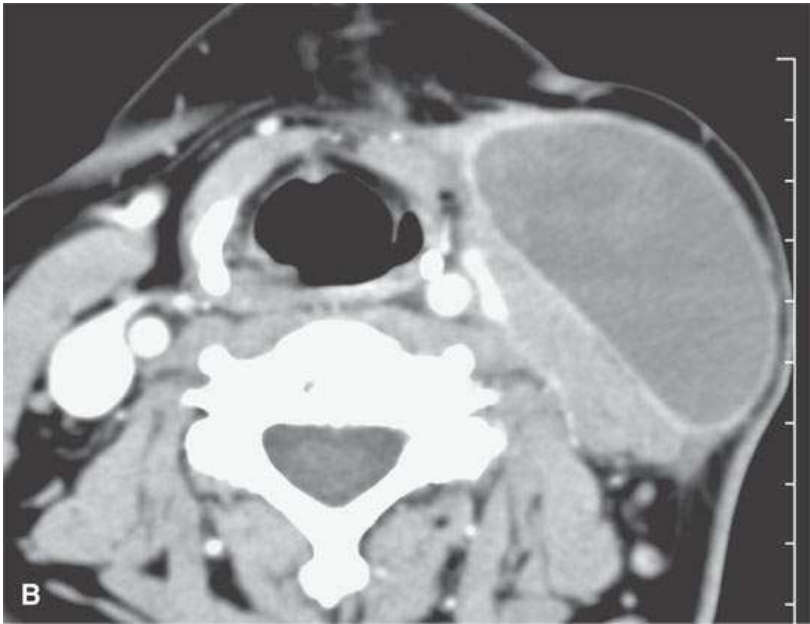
Contrast-enhanced computed tomography of a postoperative hematoma evolving to a seroma. A: Organized clot is still visible (*arrow*) within the fluid collection that has a minimally enhancing reactive pseudocapsule (*arrowheads*). B: A section lower in the neck shows only the fluid as it collects between the superficial and the investing layer of deep cervical fascia. The enhancing pseudocapsule is likely composed in part by these fascial layers (*black arrows*), reflecting that the hematoma occurred deep to the closure of the superficial fascia since it is separate from the subcutaneous fat (*white arrows*).
